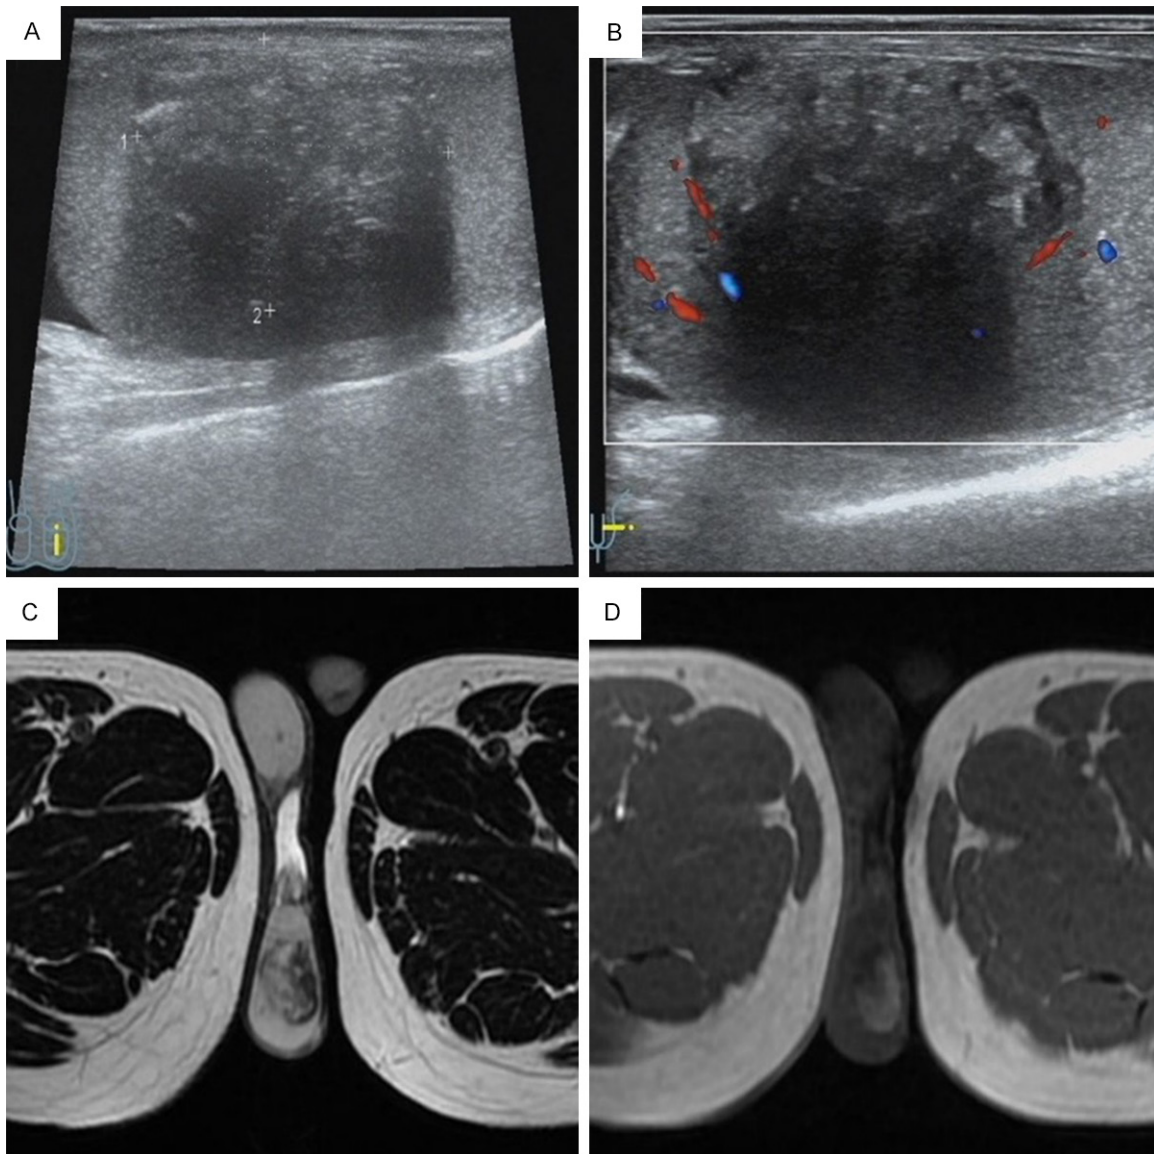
A. 2.7×2.0 cm well-demarcated intratesticular mass with alternating echogenicity. B. Sporadic blood flow signal at the rim of the mass. C. Nonhomogeneous well-demarcated lesion inside the left testis. D. Mild enhancement on contrast-enhanced MRI.
